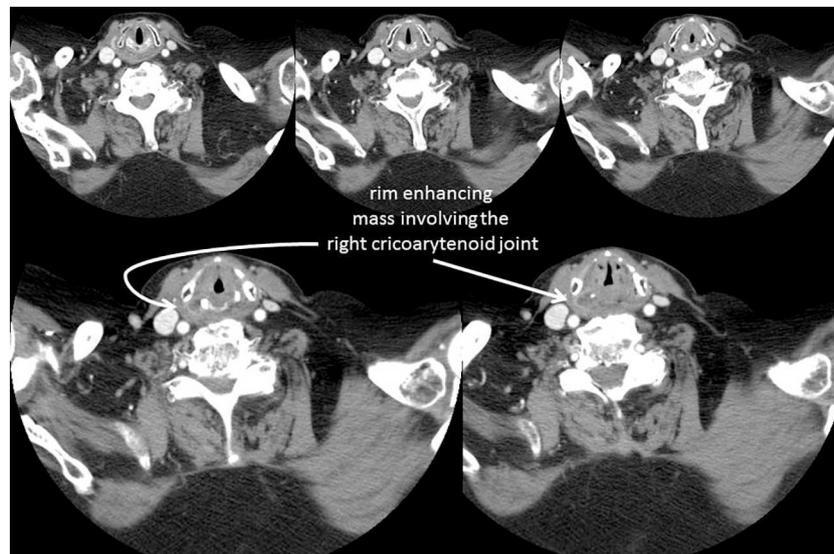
Laryngeal CT scan depicting a ring-enhancing mass involving the right cricoarytenoid joint.
